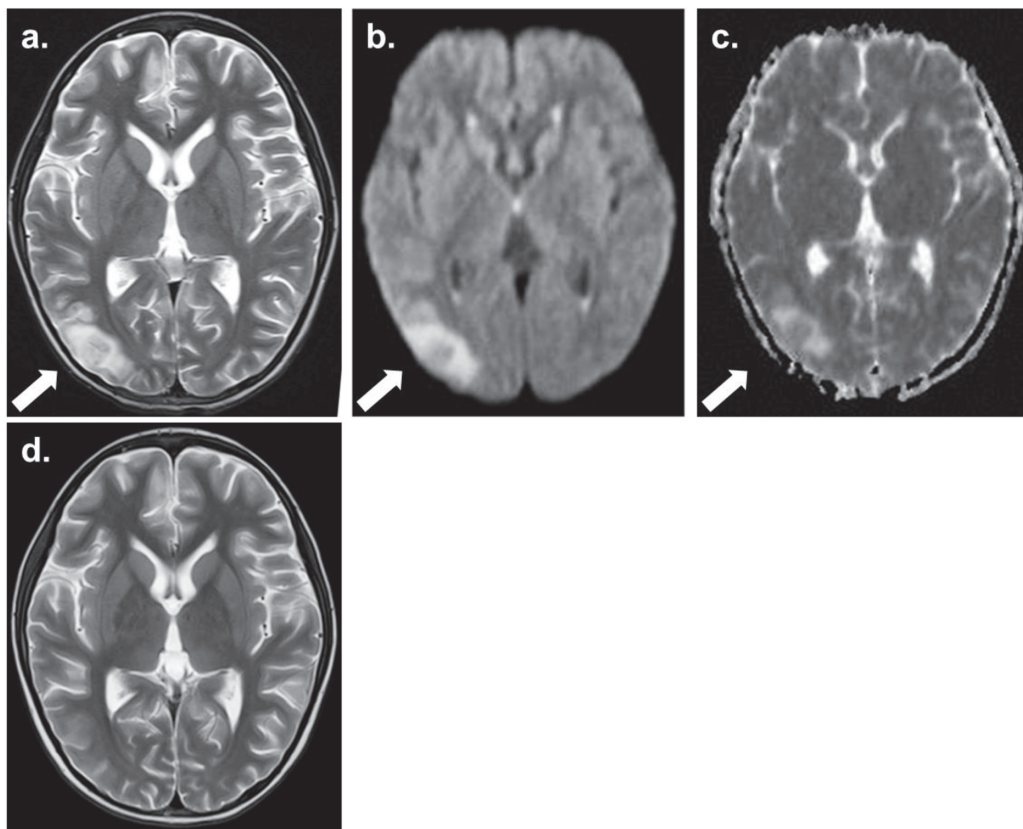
a-c) Day 29 MRI of brain showing a high intensity signal on T2WI (a), DWI (b), and ADC-map (c) in the subcortical white matter and cortex within the right parietal, temporal and occipital lobes (white arrow). d) Day 43 MRI of brain showing no high intensity signal on T2WI.
